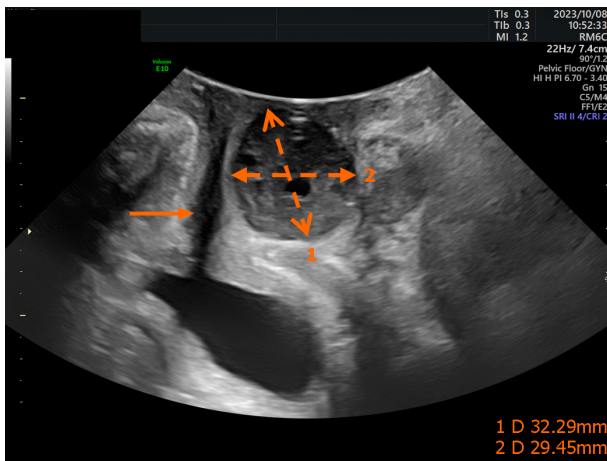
Ultrasound showing a solid mass of 3.2 cm × 2.9 cm in size involving the posterior urethra (orange arrow).
